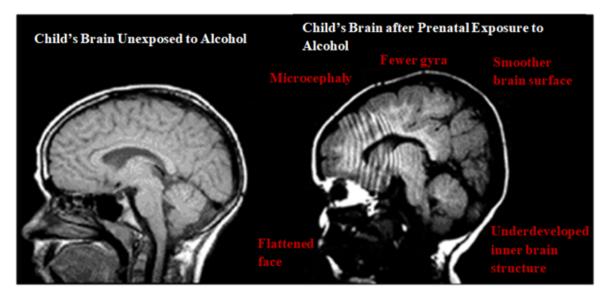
Sagittal T1-weighted MRI of a healthy child and that of a child diagnosed with FASD. Obtained from: (22)
